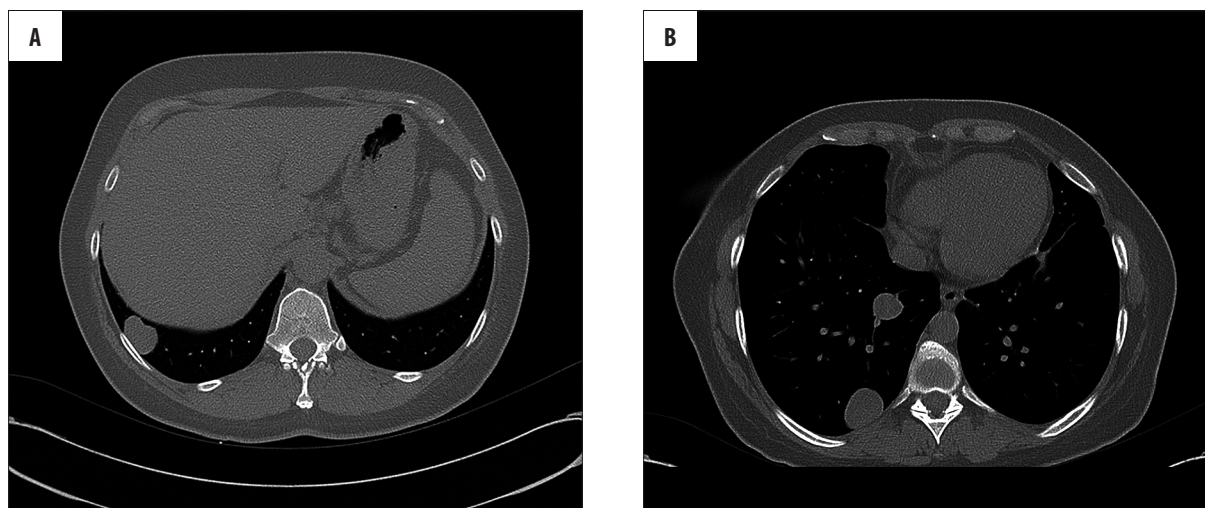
(A, B) Axial chest computed tomography scans show multiple, well-defined pulmonary nodules in the right lower lobe.
